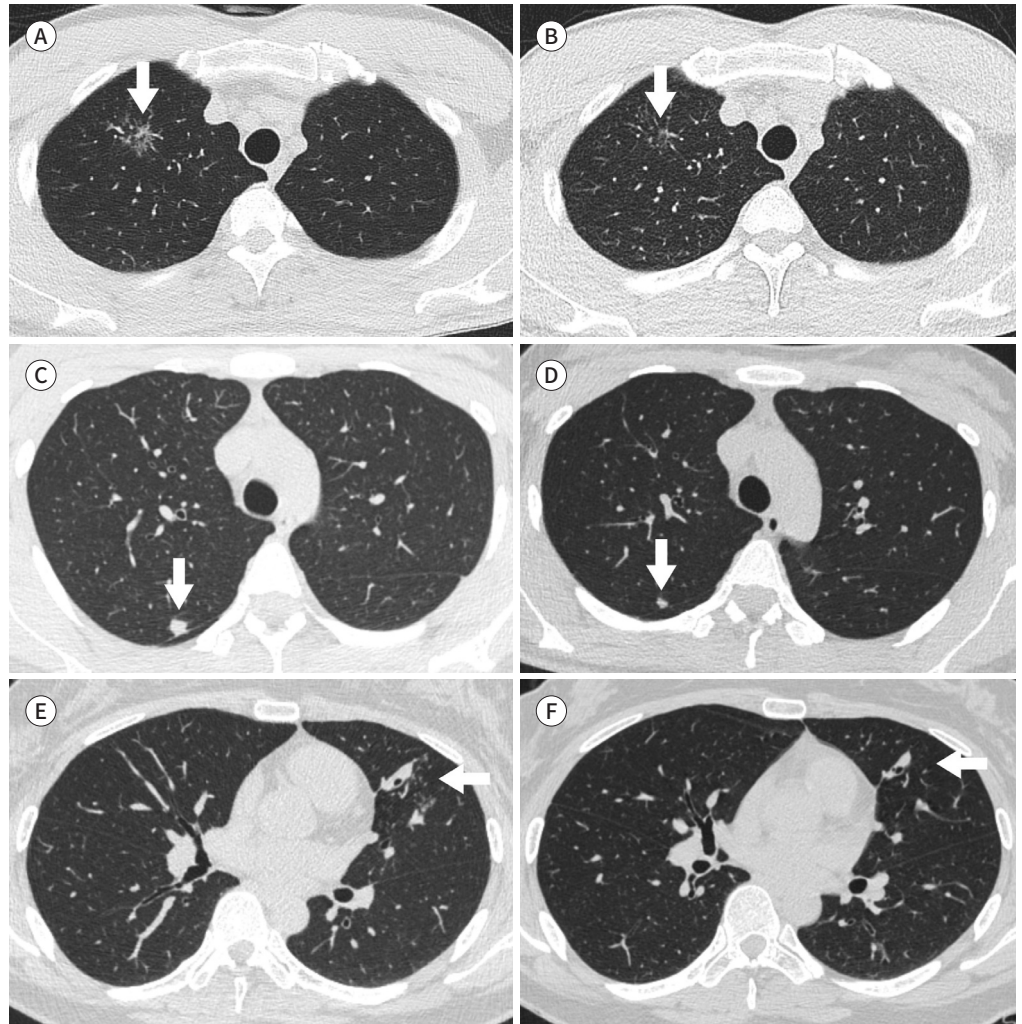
CT scans before and after empirical treatment of tuberculosis in positive interferon-gamma release assay subjects.
